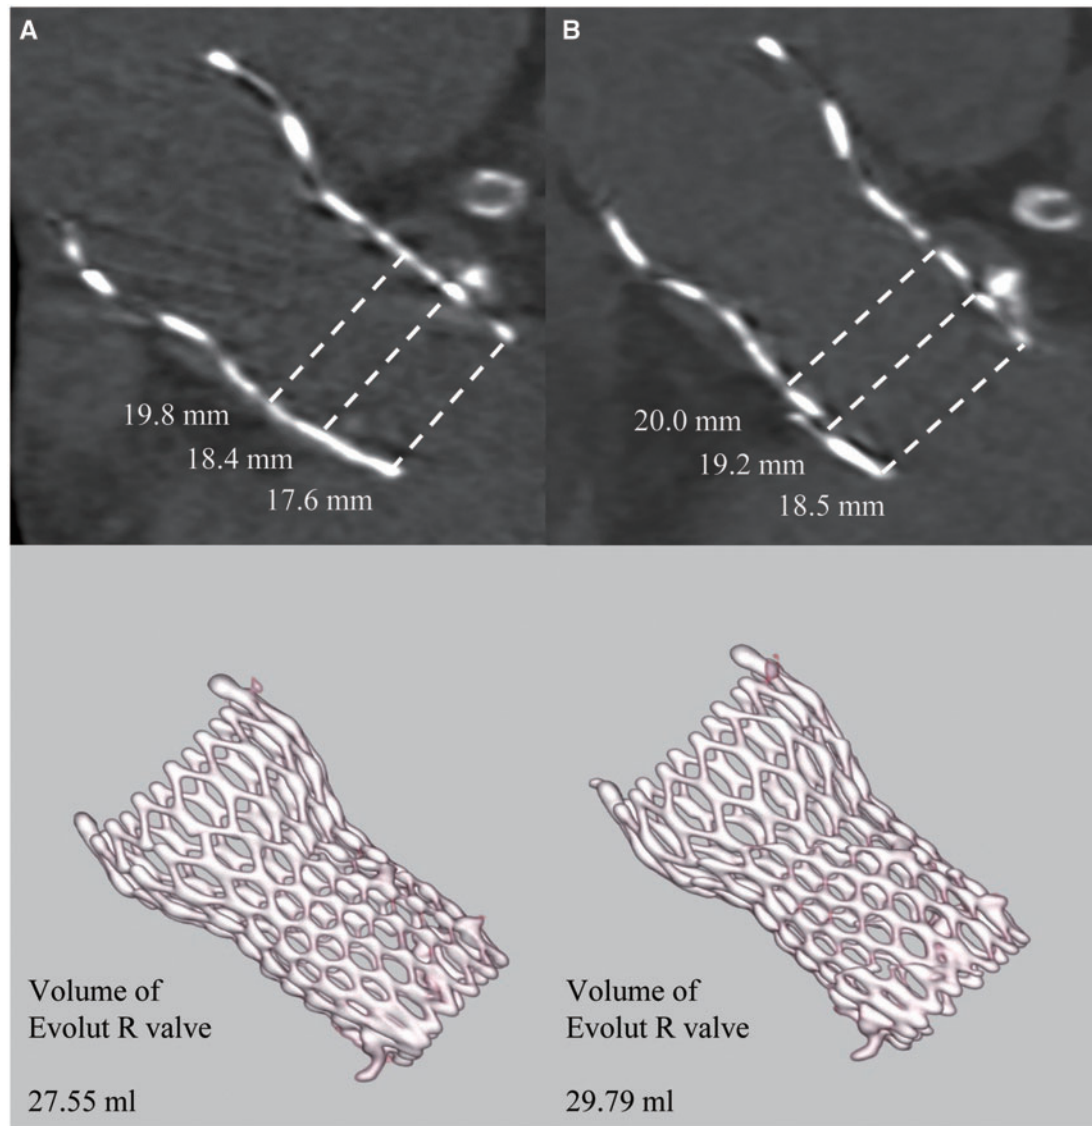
Temporal changes in the size of the Evolut R valve. Post-procedural computed tomography and volume rendering at 5 days (A) and at 3 months (B).
